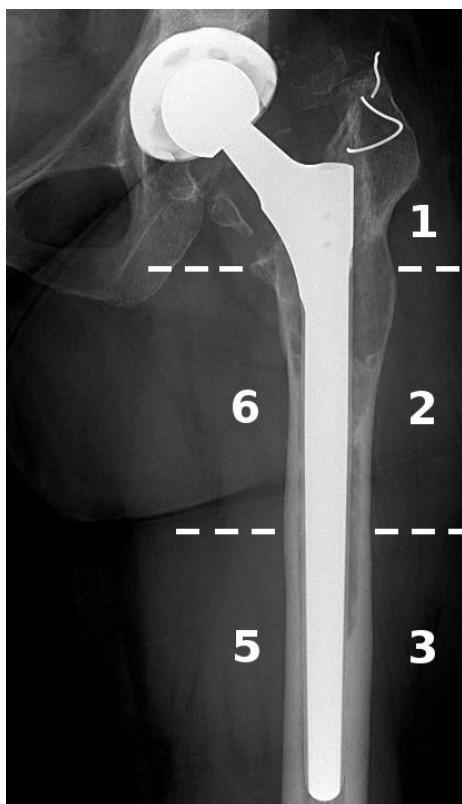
Postoperative radiograph (Patient 18) shows the evaluation of the modified Gruen zones around the revision stem
